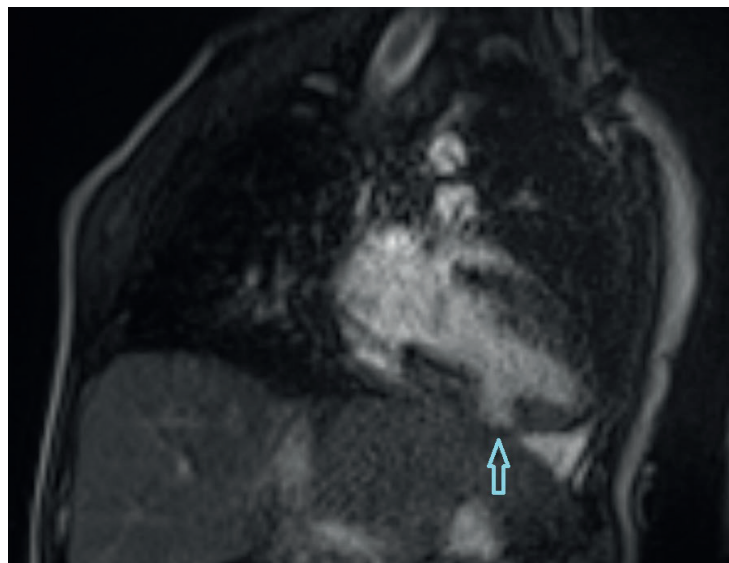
In the coronal plane, the fat-suppressed T2-weighted left two-chamber image demonstrates a 7x3mm smooth-surface, thrombus-free area of aneurysm at the junction of the interventricular septum and myocardium (arrow).
